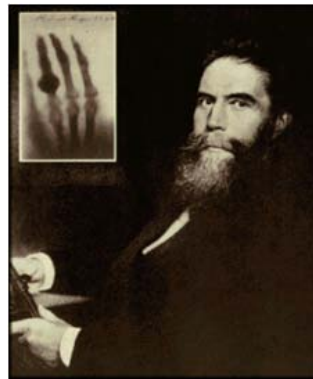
Wilhelm Conrad Röntgen (1895) with the first x-ray of his wife's hand. (Source: [AccessExcell 2012]).
